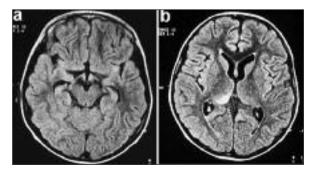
Axial FLAIR images obtained at the level of mesencephalon (a) and basal ganglia (b). Note diffuse increased signal intensity at the right thalamus.
